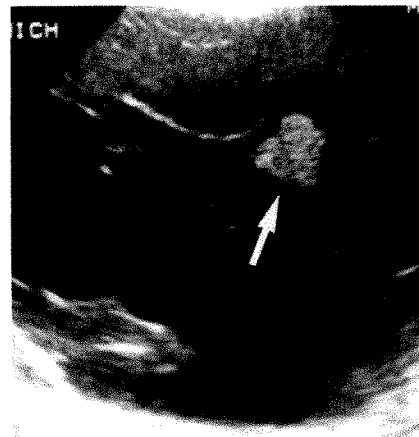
Biliary cystadenoma. Sonogram shows echogenic nodule (arrow) within septated multilocular cyst. This was the only discrete nodule or mass seen in the eight benign cystadenomas.
